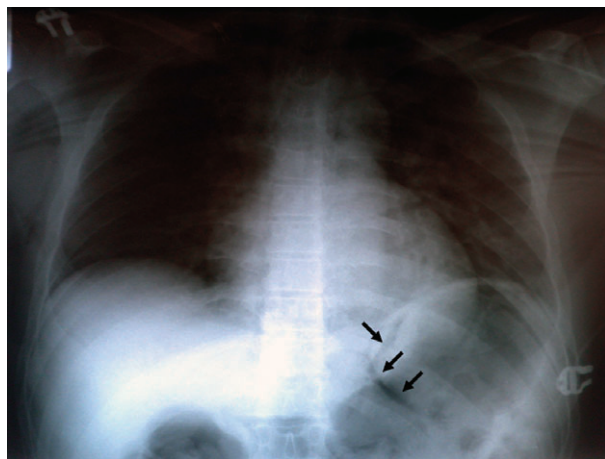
Chest X-ray image relating to case 2. The arrows point to free air surrounding the fundus or the stomach, supporting the previously suspected perforation of the lower esophagus.
